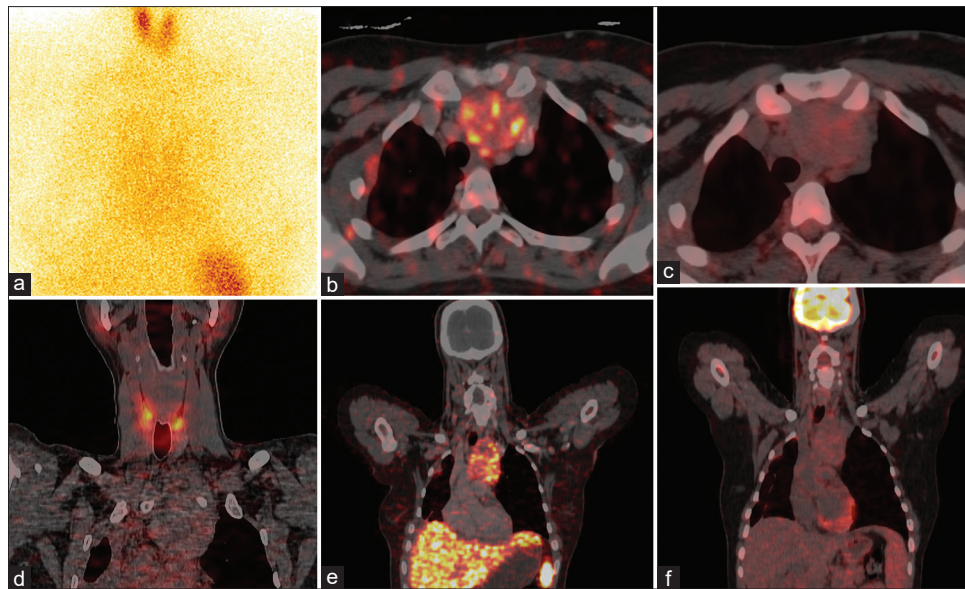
(a,d) ^{99m}Tc -pertechnetate scan with SPECT/CT shows tracer uptake in normal cervical thyroid gland with no significant uptake in mediastinal mass. (b,e) On ^{68}Ga -DOTANOC PET/CT a well-defined, heterogenous density tracer avid mass was noted in the superior and anterior mediastinum on the left side extending with low FDG avidity on ^{18}F -FDG PET/CT (c,f)
